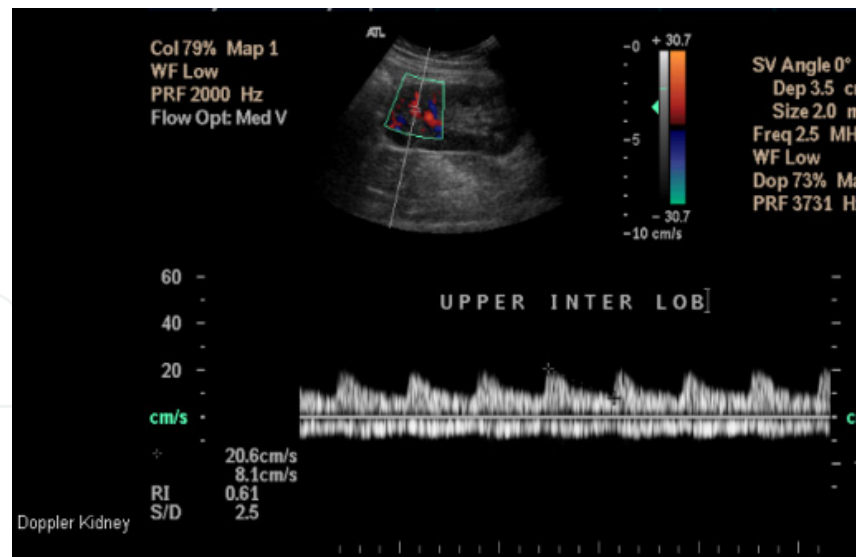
Post revascularization intrarenal Doppler. Normal waveform is seen confirming successful restoration of blood flow.
